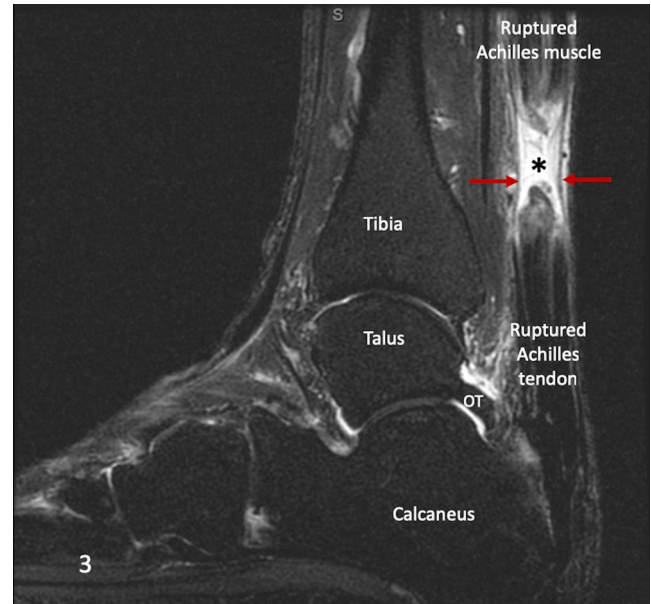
Sagittal fast spin echo STIR MR image of the right ankle. The full-thickness rupture of the Achilles tendon at the myotendinous junction is noted by the edematous cleft (*). This gap measures 2 cm. The paratenon (red arrows) remains intact. An os trigonum (OT) is incidentally noted
